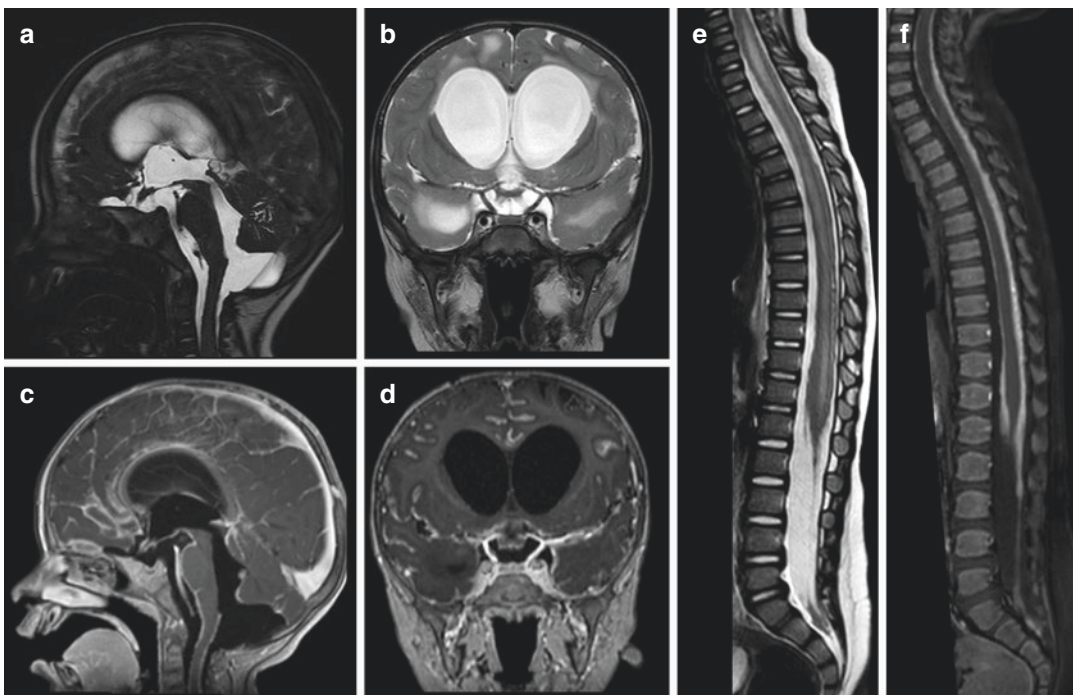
Leptomeningeal carcinomatosis. Brain T2-weighted (a and b) and gadolinium-enhanced T1-weighted images on sagittal and coronal planes (c and d) show diffuse leptomeningeal enhancement along the pial surface of the brain stem and basal cisterns, ventricular ependymal surfaces, cerebral sulci, and cerebellar folia, resulting in hydrocephalus. Spinal sagittal
